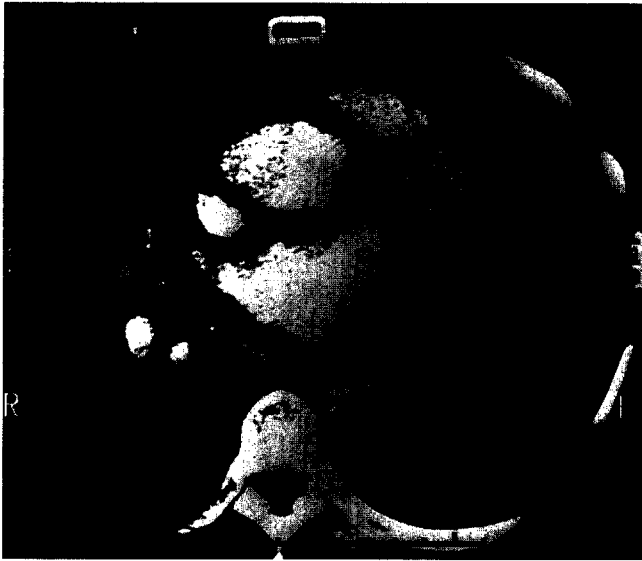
Spiral CT scan with contrast of patient 6 showing the dilated main right and left pulmonary arteries. Clots (arrows) are seen in the right intralobar artery (A), right lower lobe pulmonary artery (B), and left lobar artery (C).
